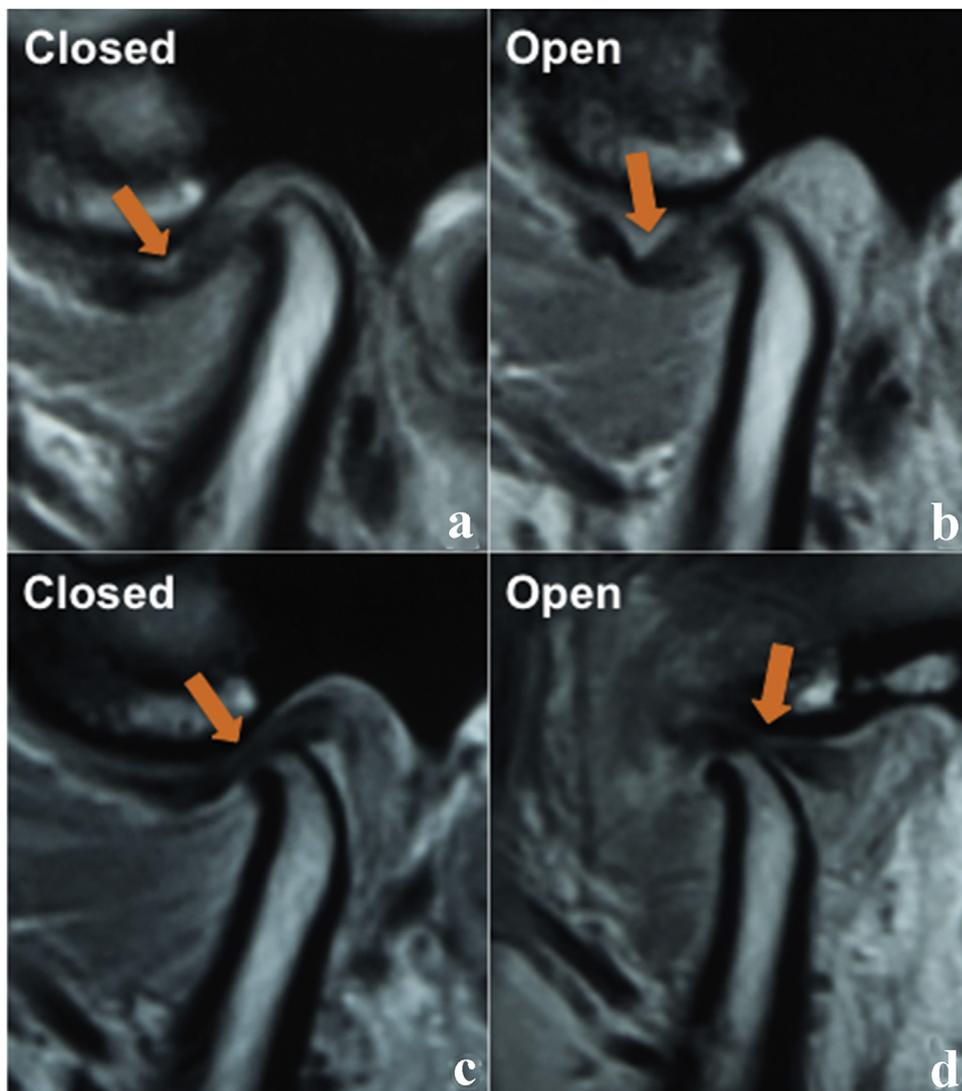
MRI images showing successful disc reduction in a joint with DDwoR. Images (a) and (b) show the pre-treatment condition, with the disc displaced anterior to the condylar head in both the closed and open mouth positions. Images (c) and (d) show the post-treatment condition, with a normal disc–condyle relationship in both the closed and open mouth positions. Note that the posterior band of the disc is located underneath the highest point of the glenoid fossa in the closed position.
